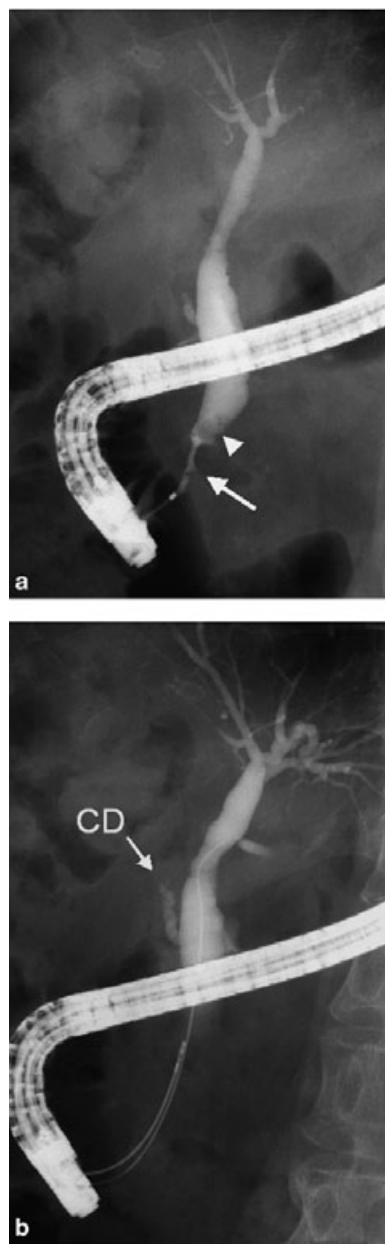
a Endoscopic retrograde cholangiopancreatography reveals an irregular stenosis (arrow) of the distal common bile duct and a filling defect (arrow head). b An ultrasonic probe is inserted into the bile duct along with a guide-wire through a biopsy-channel of a duodenoscope. CD, cystic duct.
